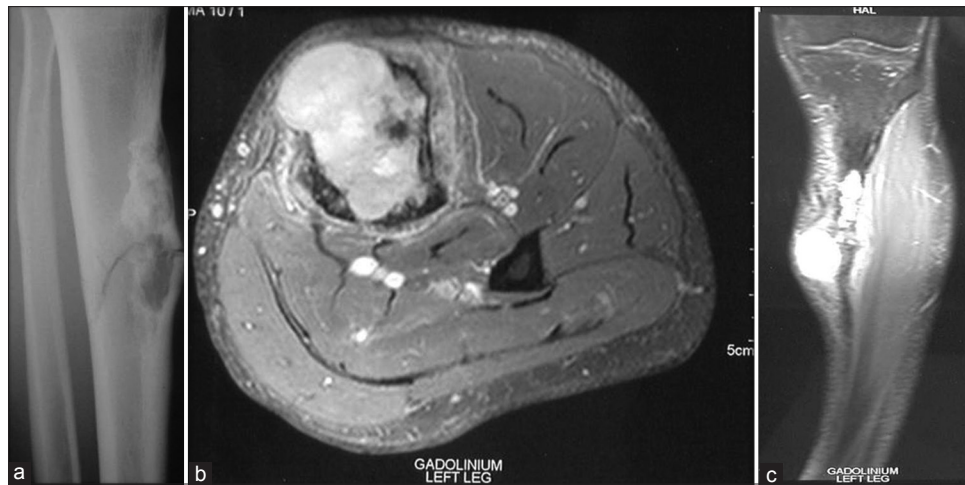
(a) Planar X-ray of left tibia, (b) Magnetic resonance imaging transaxial cut of proximal left tibia, (c) Magnetic resonance imaging left tibia
